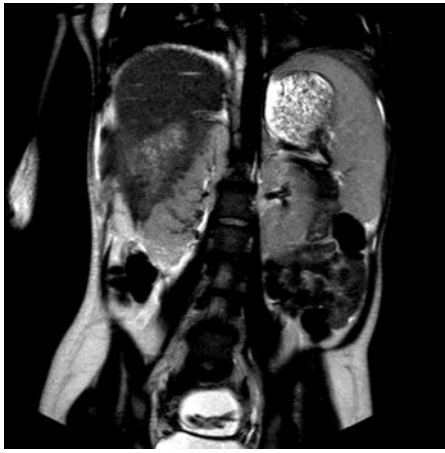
Non-contrast magnetic resonance imaging of abdomen and pelvis: heterogeneous mass 11.2×7.7 cm arising from right kidney extending to liver edge, splenomegaly with spleen measuring 15.2 cm and mild right hydronephrosis.
